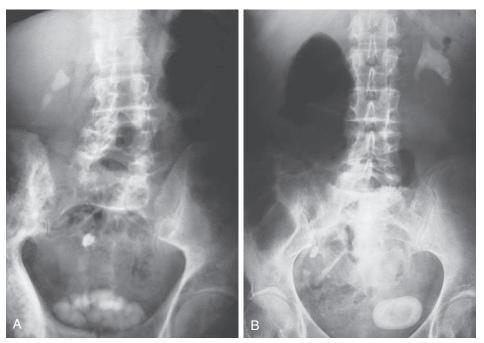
Radio-opaque renal calculi. (A) X-ray film showing multiple cystine stones in the right kidney, right ureter, and bladder. (B) Struvite stones: left staghorn calculus and a single bladder stone.
